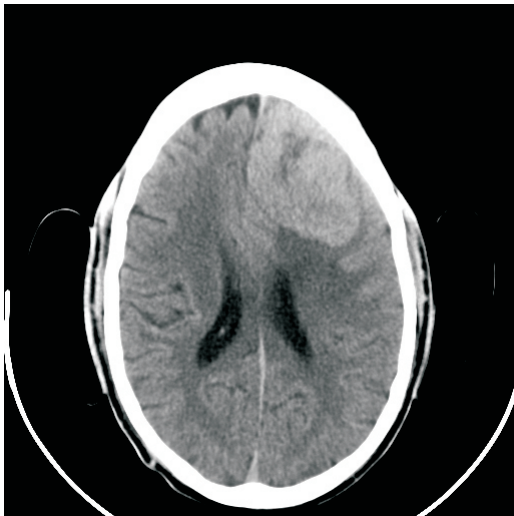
Plain cranial CT scan showing huge hyperdense lesion involving the left frontal lobe. The lesion arises from the anterior part of the falx cerebri. There is an area of hypodensity within it suggesting tumor necrosis. There is effacement of the ipsilateral ventricle and the sulci with minimal midline shift.
